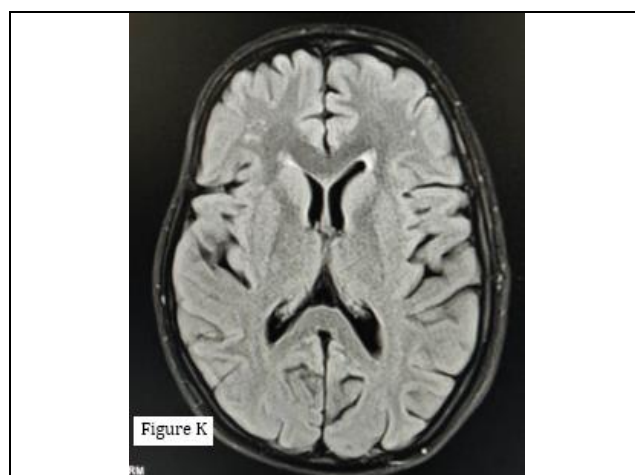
Axial FLAIR image showing few discrete hyperintensities in white matter of bilateral frontal lobes.
